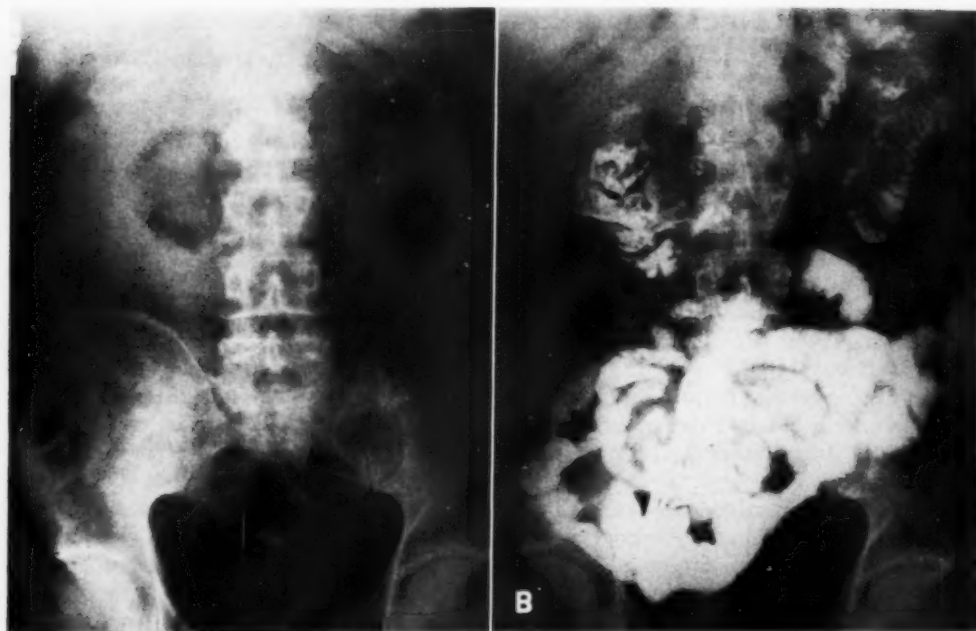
Case I. A. Roentgenogram showing sharply demarcated soft-tissue mass in right upper and mid abdomen, with central radiolucent area outlining thickness of residual tumor. B. Upper gastrointestinal study demonstrating barium filling the necrotic portion of the tumor. The site of fistulous communication in the second portion of the duodenum is outlined.
